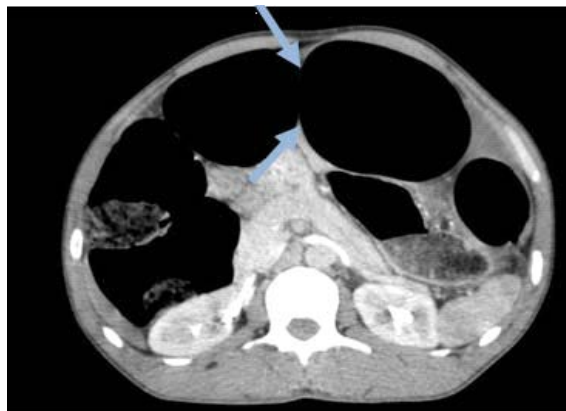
Abdominal CT axial cut with PDC injection showing distended loops with haustrations (arrow) indicating their colic nature.
